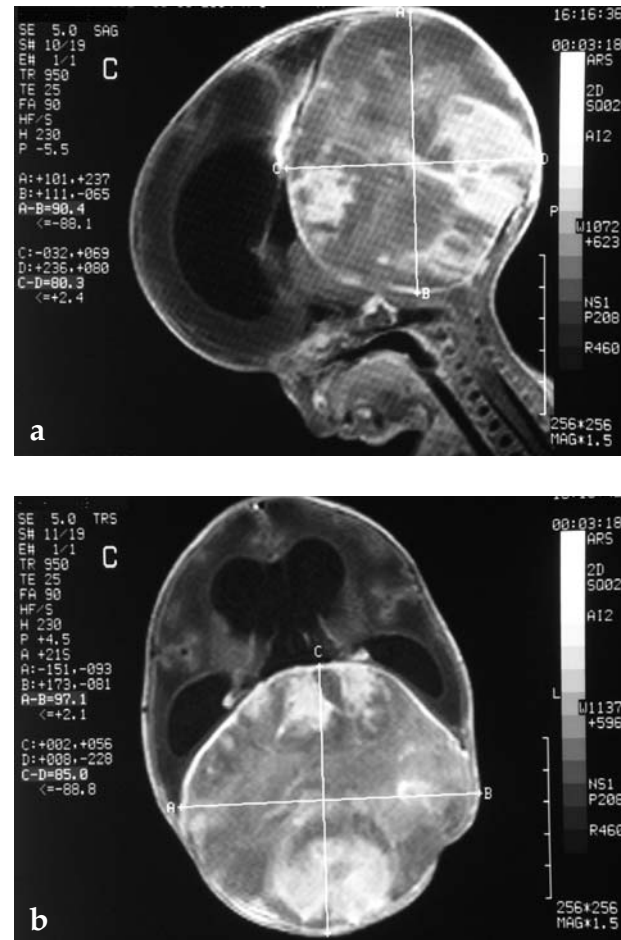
Postnatal MR images. Large tumor located in the posterior fossa measuring 9x8 cm in diameter, and ventricular dilatation
